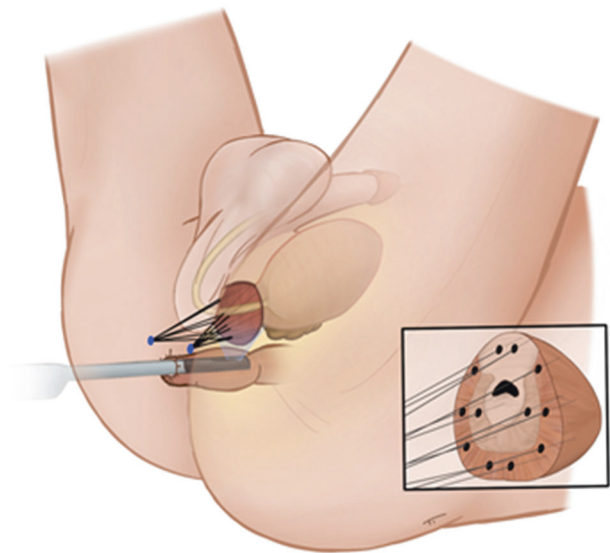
The two perineal entry points allow to biopsy all areas of the prostate under transrectal ultrasound guidance. The fan technique enables to obtain biopsies from the whole gland and make especially anterior targets easily accessible.
